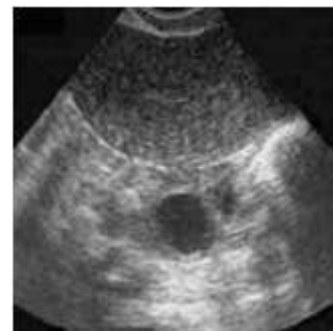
Ultrasound image of ovary with follicles
